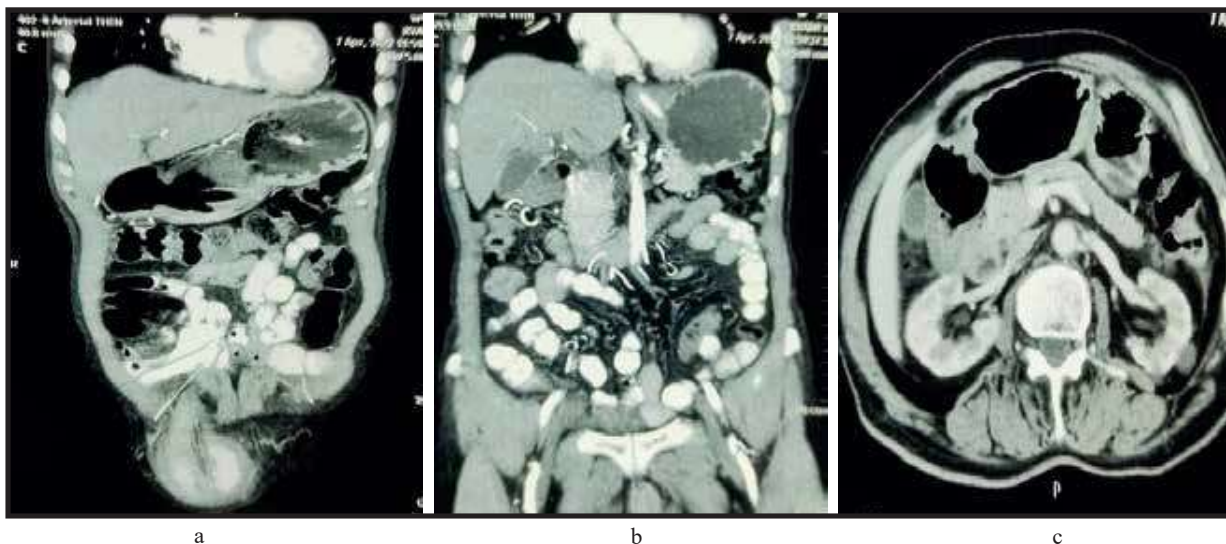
Figure - a,b,c shows abdominal CT scan with soft tissue thickening in arrow mark.
